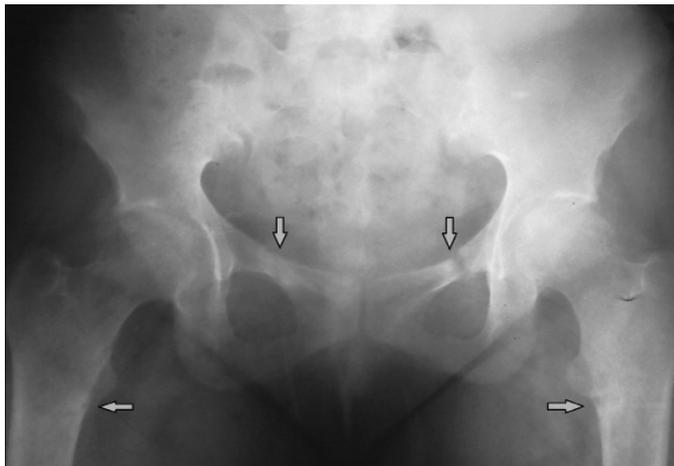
Radiograph of the patient showing symmetric fracture zones in both superior pubic rami and inner margins of the femoral neck.
